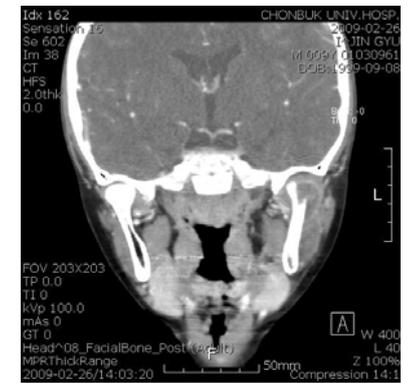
Coronal view of CT
